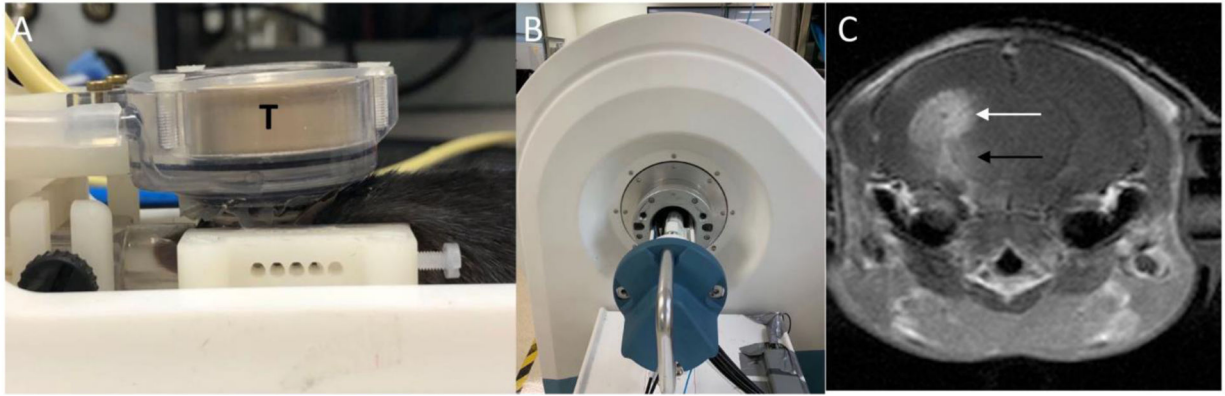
Experimental apparatus and post contrast T1-weighted image immediately after sonication.
